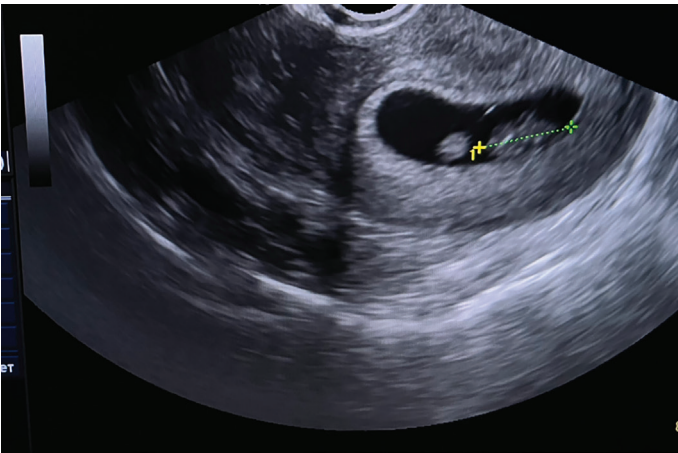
Ultrasound scan
